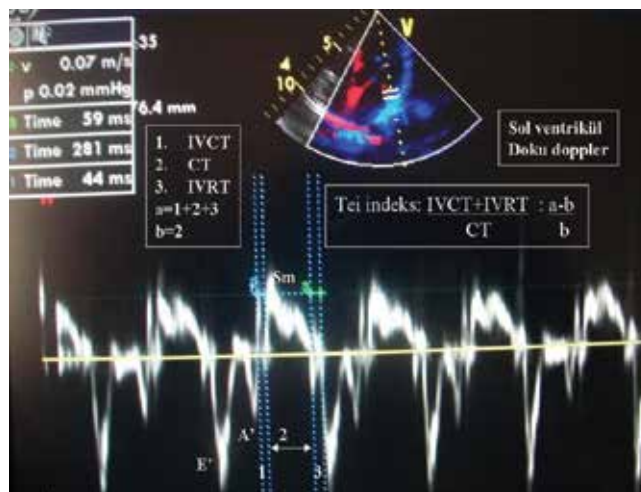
Calculation of Tei index on tissue Doppler echocardiography
